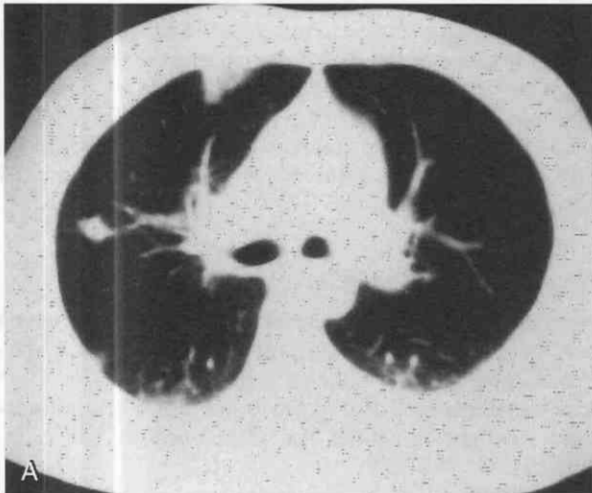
A and B, Tuberculosis in a patient with acquired immunodeficiency syndrome (AIDS). CT shows multiple inflammatory lung masses and bulky mediastinal nodes (arrows) resulting from tuberculosis (TB). Lymphadenopathy is the rule rather than the exception in patients with AIDS and TB. (From Kuhlman JE: CT evaluation of the chest in AIDS. In Thrall J [ed]: *Current Practice in Radiology*. St. Louis, Mosby-Year Book, 1993.)
